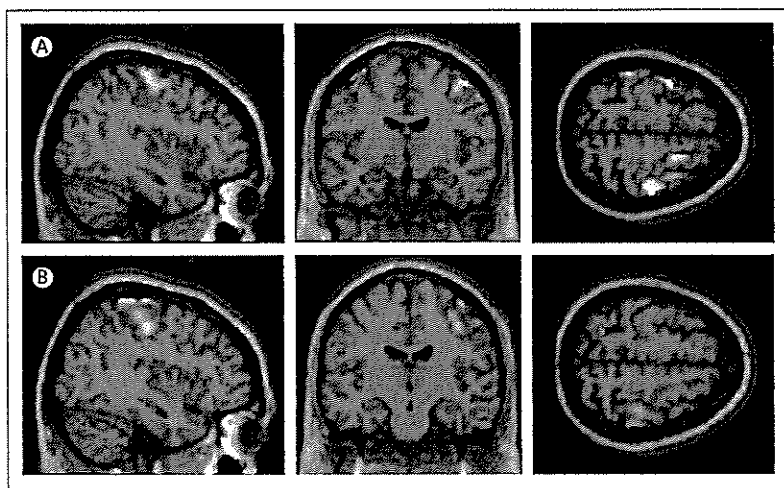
Functional MRI scans show abnormal activation in the brain. Average activation during finger tapping with the left hand in three adolescents with increased prenatal methylmercury exposure (A) and three control adolescents (B). The control participants activate the premotor and motor cortices on the right, whereas participants exposed to methylmercury activate these areas bilaterally.³¹
